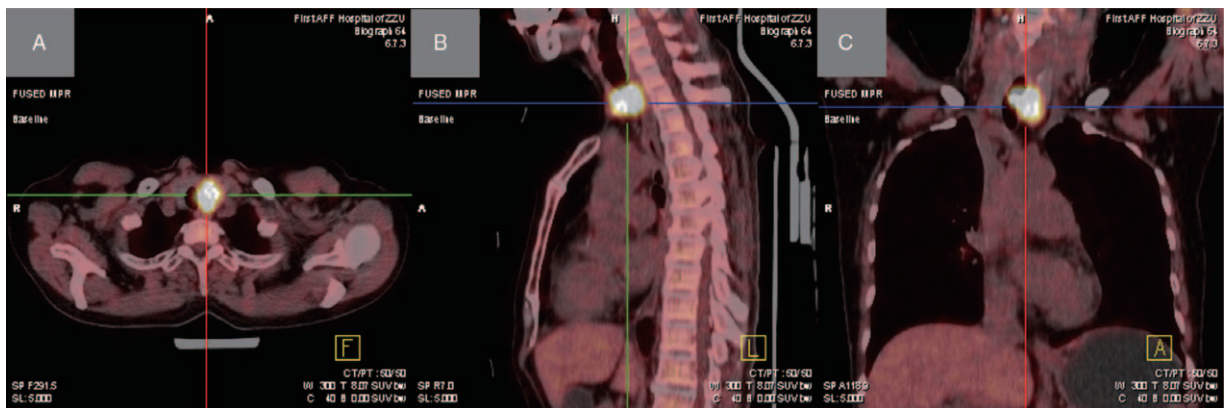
Positron emission tomography–computed tomography scan. (A) The axial image showed a soft-tissue mass with intense radioactivity on the left lobe of the thyroid gland; (B) the sagittal image showed an intensely radioactive soft-tissue mass blocking most of the upper endoluminal trachea; (C) the coronal image showed that the trachea was compressed to the right side, and part of the mass protruded into the lumen, which can result in the stenosis observed in that area of the trachea.
